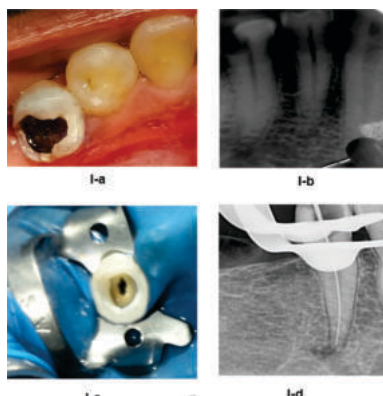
Figure-I (a) and (b): Pre-operative photograph and radiograph (c): Pre-endo build up and access opening under rubber dam isolation (d): Working length determination
